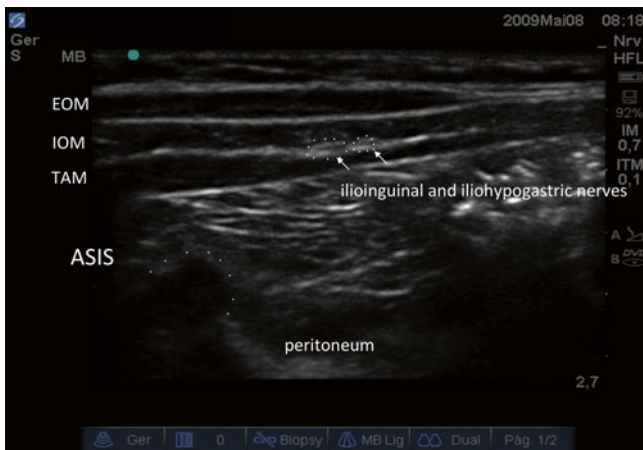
Ultrasound image of ilioinguinal and iliohypogastric nerves at the iliac crest. *ASIS* anterior superior iliac spine, *EOM* external oblique muscle, *IOM* internal oblique muscle, *TAM* transverse abdominis muscle (Image courtesy of Thiago Nouer Frederico, MD, modified by Charles de Oliveira, MD)
